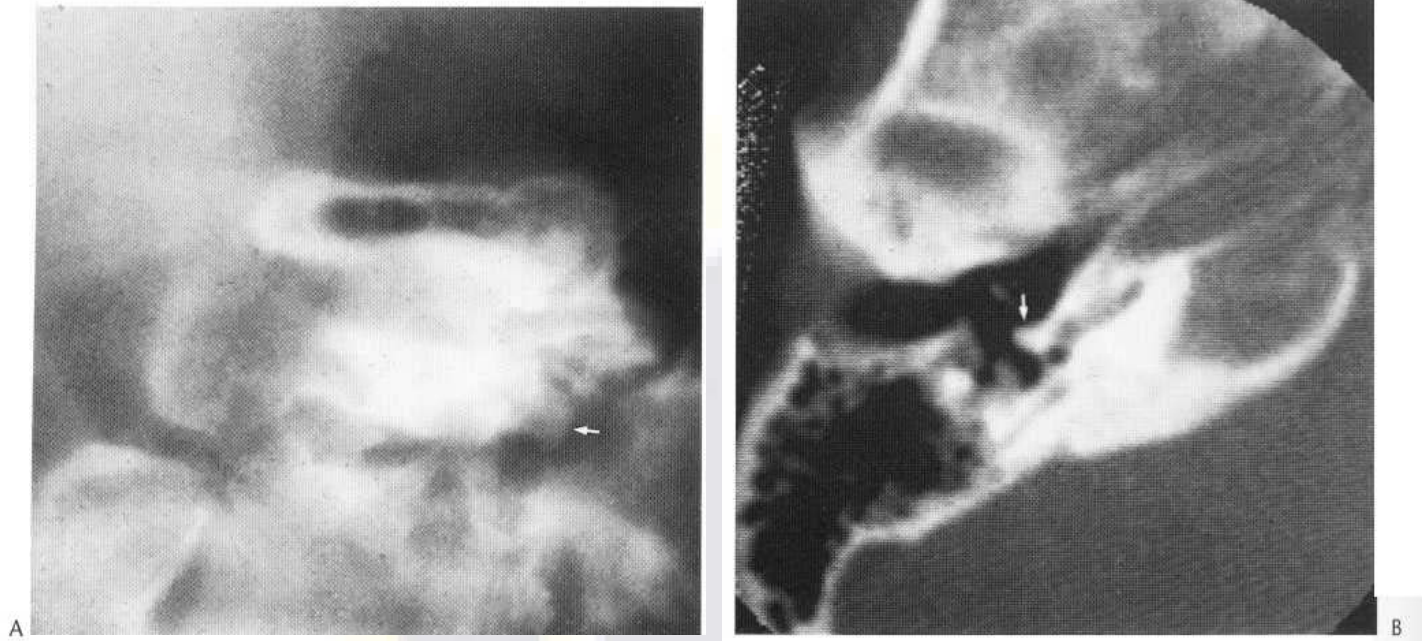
A small osteoma of the middle ear arising from the posterior aspect of the promontory close to the round window. (A) Coronal tomogram shows the osteoma just below the incudostapedial joint. (B) Axial CT also shows the relation to the basal turn of the cochlea.
